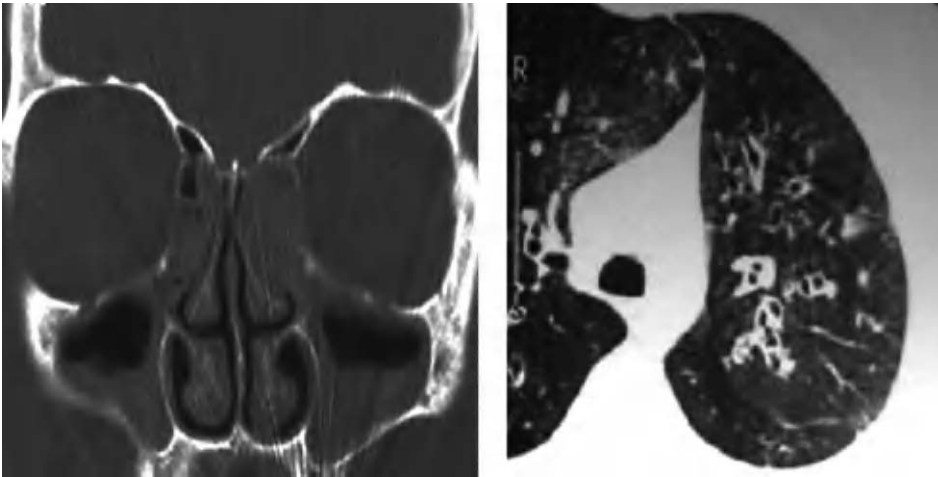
Chronic rhinosinusitis in the bilateral maxillary ethmoidal region (computed tomography scan of the sinus) beside a bilateral bronchiectasis (lung scan) in the same patient.
